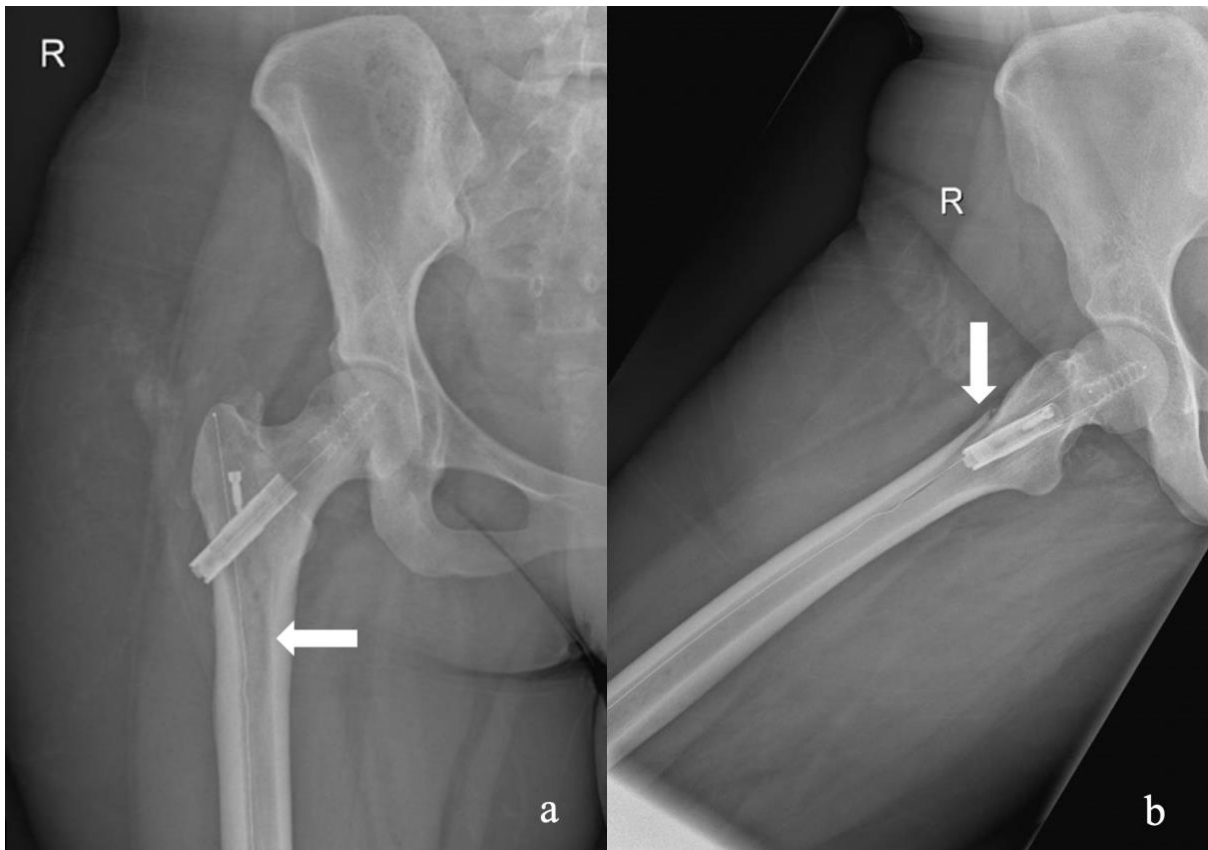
AP (a) and lateral (b) right femoral radiographs of Patient X with pathological fracture subsequent to prophylactic femoral CFR-PEEK IM nail.
